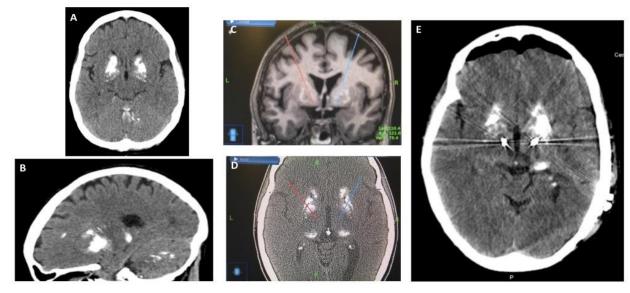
Preoperative CT-scan showing extensive bilateral brain calcifications, mainly in the basal ganglia, thalamus and cerebellum
